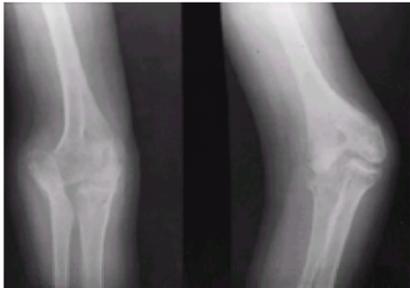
Unusual bony abnormalities in the elbow radiograph from the patient shown in [Fig. 13](#). The radial head on the left in particular is grossly abnormal.
